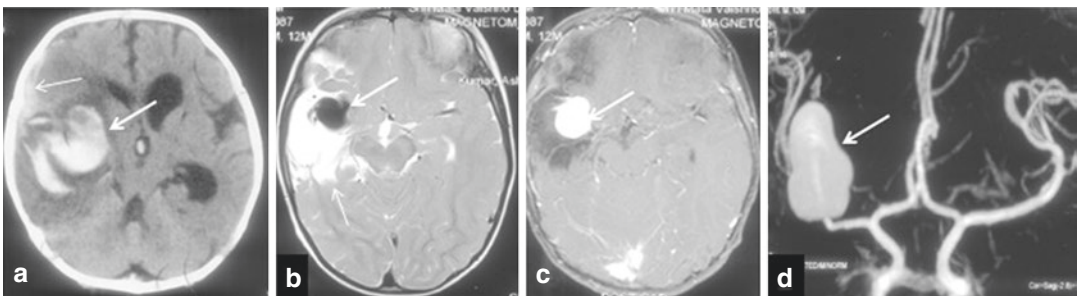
In a 4-year-old child, axial NCCT head showed (a) well-defined hyperdense lesion (thick white arrow), s/o bleed with perilesional hypodensity (edema) in right temporal lobe with thin SDH in right temporal lobe convexity (thin white arrow). Axial T2 MRI showed (b) well-defined flow void in right distal M1 MCA (thick white
